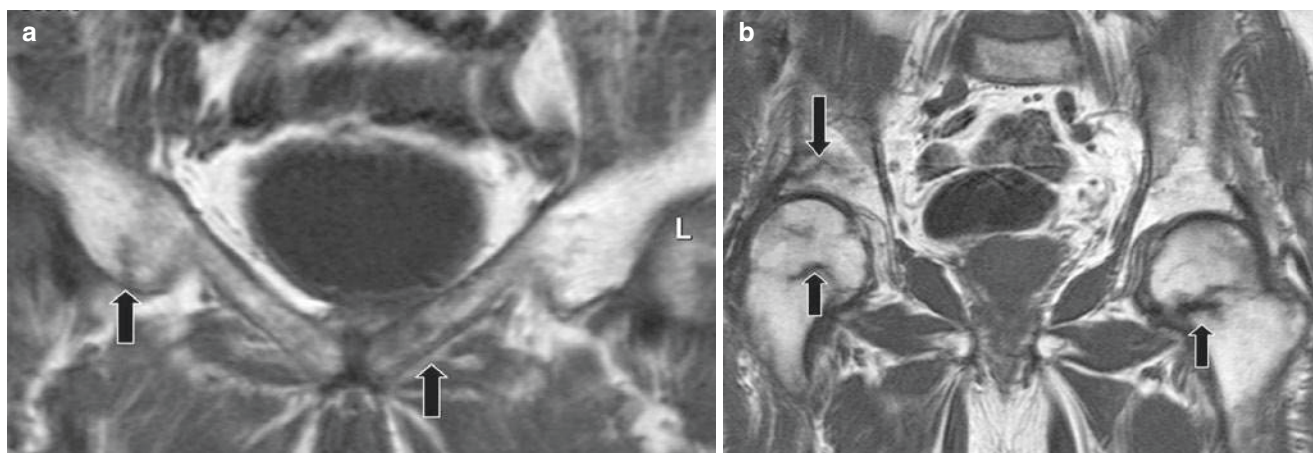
Osteomalacia. (a, b) Coronal T1-weighted images of the pelvis of a patient with osteomalacia demonstrate multiple trabecular bone fractures (arrows)
